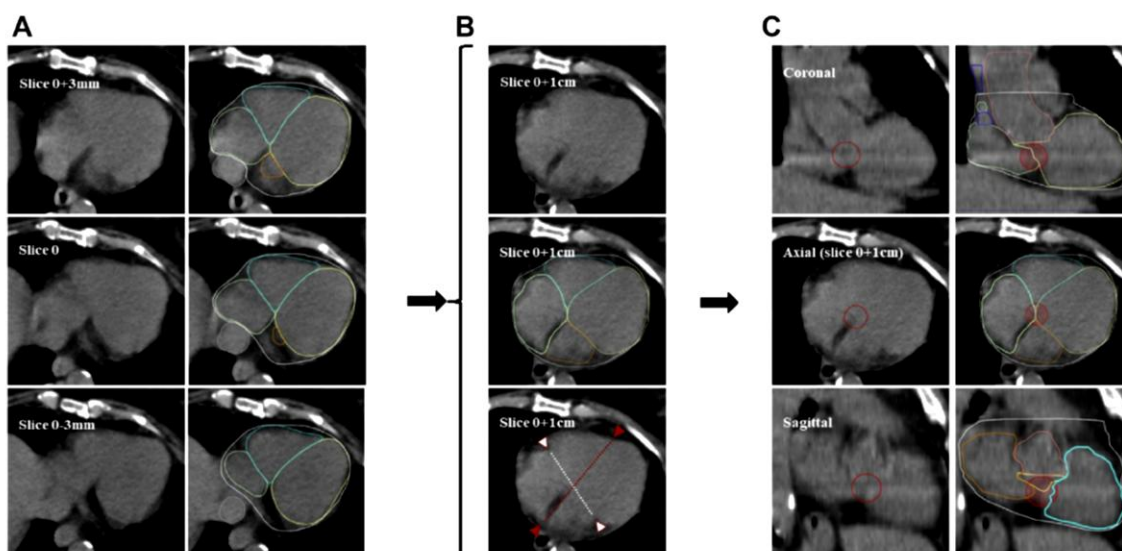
Step-by-step delineation of the atrioventricular node (AVN). The slice thickness is 3 mm. The heart (white), aorta (pink), superior vena cava (SVC; blue), inferior vena cava (gray), right atria (light green), left atria (orange), right ventricle (cyan), and left ventricle (yellow) have been delineated. (A) Identify the lowest computed tomography (CT) slice where the left atrium is visible, posteriorly to the left ventricle (identified as Slice 0 on the provided example). (B) Scroll up to the CT slice situated 1 cm above (identified as Slice 0 + 1 cm). On this slice, the left and right atrioventricular grooves (white triangles) and interatrial and interventricular grooves (red triangles) can be identified without contrast media injection. The atrioventricular groove plane is materialized by the white dotted line between the atrioventricular grooves and septal plane by the red dotted line between the interatrial and interventricular grooves. Identify the intersection of these 2 planes. (C) The AVN is delineated by the 2-cm diameter sphere centered on the intersection of the atrioventricular groove and septal planes on this slice (Slice 0 + 1cm). The AVN spherical contours (red) are provided in the coronal, axial, and sagittal planes.
